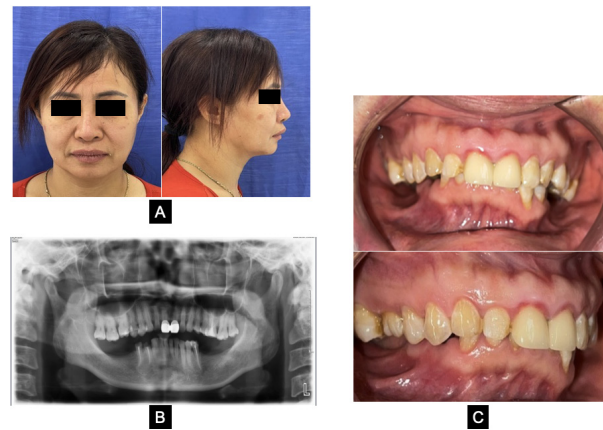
Case 1. Before treatment (female patient), frontal and lateral views of the face (A), panoramic radiograph (B), and intraoral frontal and right lateral view (C).
